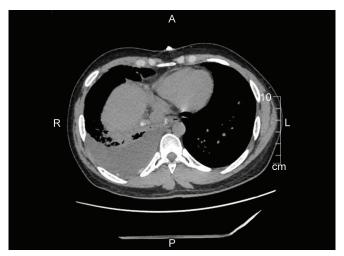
CT chest cut showing moderate right pleural effusion with underlying lung collapse
